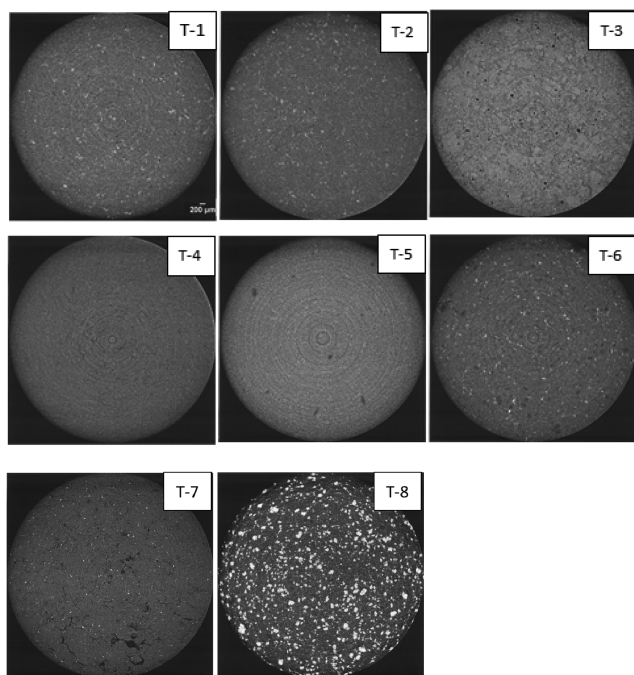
X-ray computed tomography images of the internal structure of tablets T-1 to T-8.
